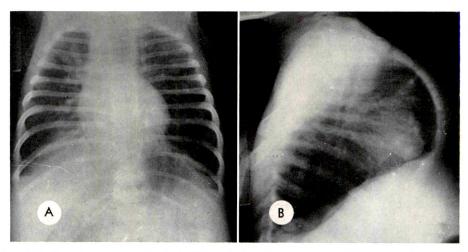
(A and B) Roentgenograms of a male child who had had diarrhea since the age of 1 month, admitted at 10 weeks with "bronchiolitis." The lungs are markedly overdistended, the anteroposterior thoracic diameter much increased.
